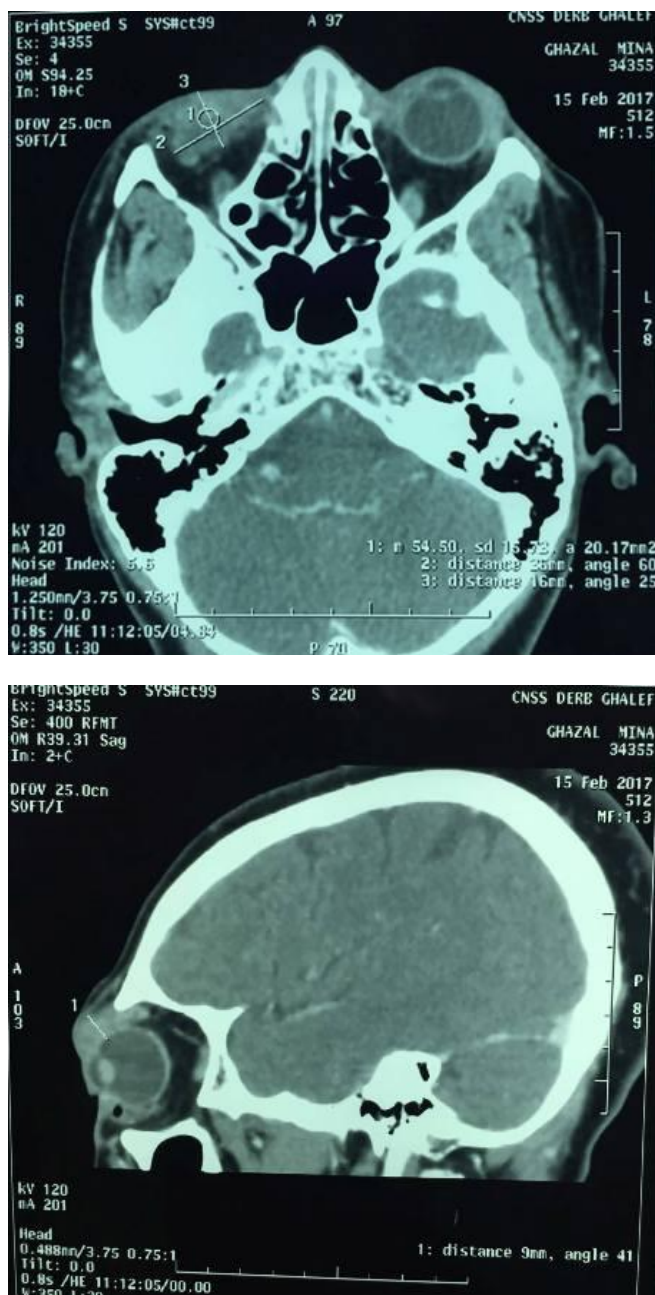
Craniofacial CT: A: axial cut, B: sagittal cut
